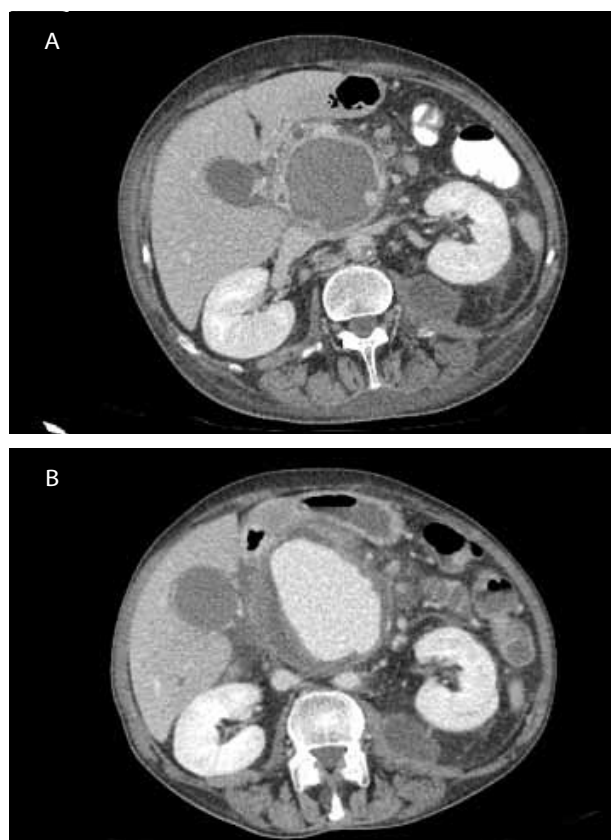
Computed tomography angiography (CTA) of the superior mesenteric artery in transverse section at the first (A) and second (B) hospitalisation.
